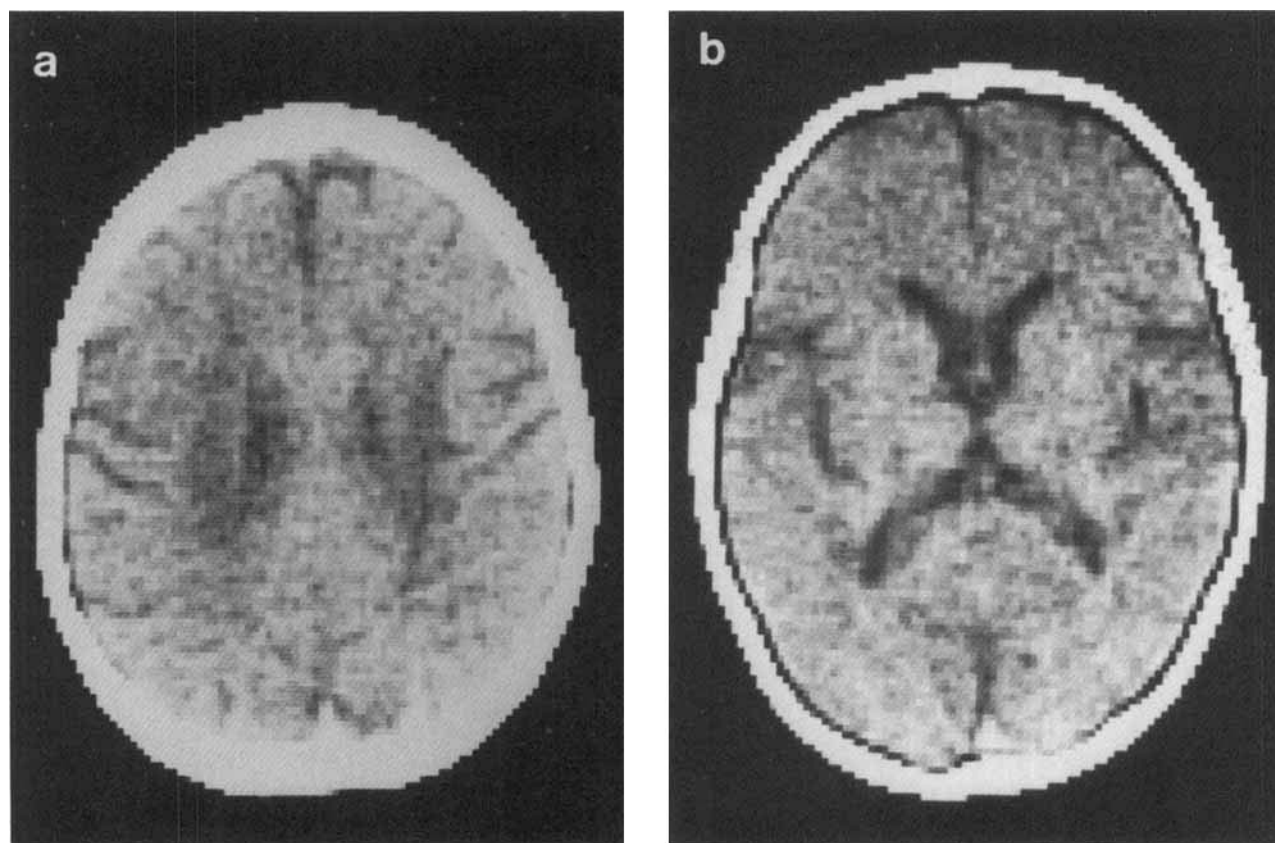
CT in KD, late-onset form. Case 4. Four-year-old child with spastic tetraparesis. a: Axial CT at foramen of Monro. Slight hyperdensities of basal ganglia and decreased density of pyramidal tract within internal capsules. Slight ventricular enlargement. b: Axial CT at roof of lateral ventricle. Marked, central hypodensity of white matter. Subcortical U-fibers not affected.
